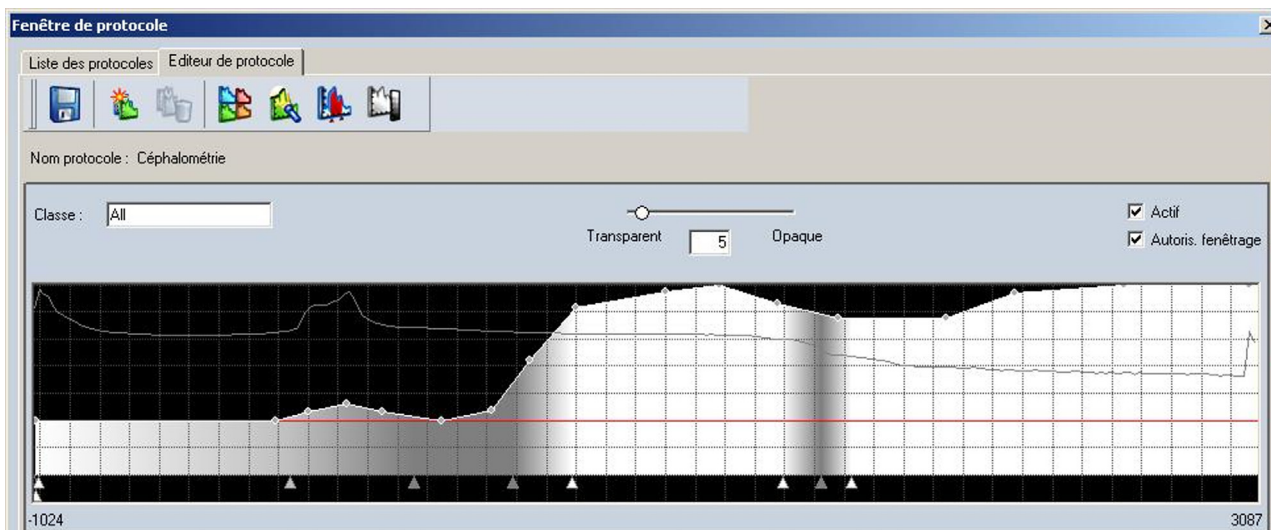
Modified volume rendering protocol on Carestream[®], adapted for the generation of 2D lateral cephalograms using CT 3D data.
